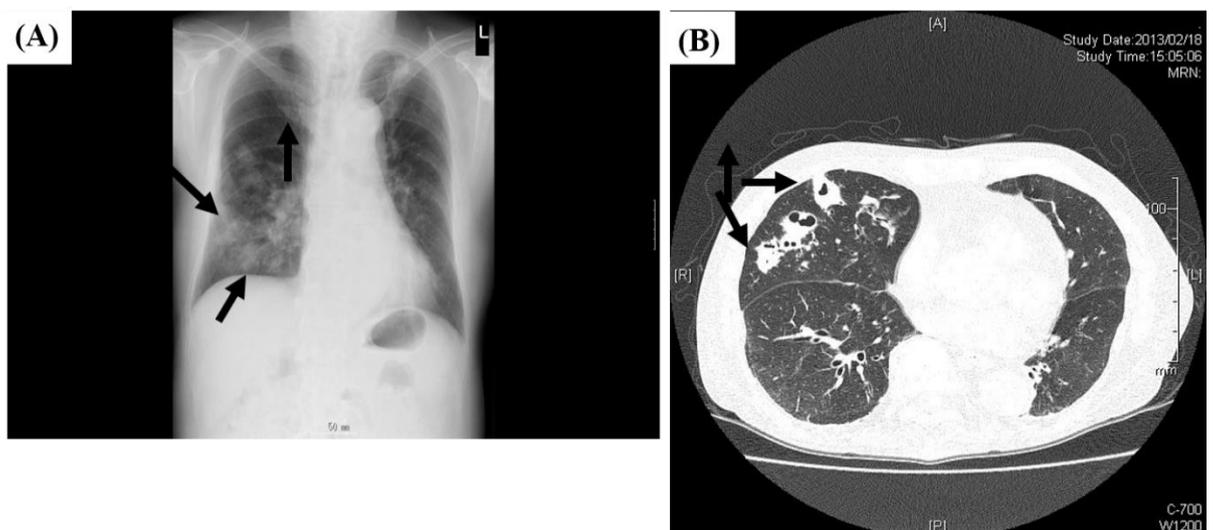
Chest X-ray (A) and CT (B) of the case 2 patient on admission. Peripheral nodular shadows with cavities in the right lung field are found based on the slight ground-glass opacity lesions (Figure 2A,B)
